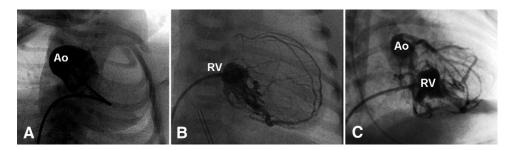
The first views. The diagnosis of PAIVS is typically by fetal ultrasound and at that time an estimation of the degree of right heart hypoplasia can be made. Although RV-CACs are not often seen in utero, they are commonly present with severe right-heart hypoplasia and their presence can often be inferred. Ligation will require fairly precise localization, however, and more definitive studies are required postnatally. If the postnatal transthoracic echocardiogram confirms the presence of RV-CACs, angiograms will be very helpful. During the catheterization studies, pulmonary blood flow will be maintained by prostaglandin E_1 infusion.
